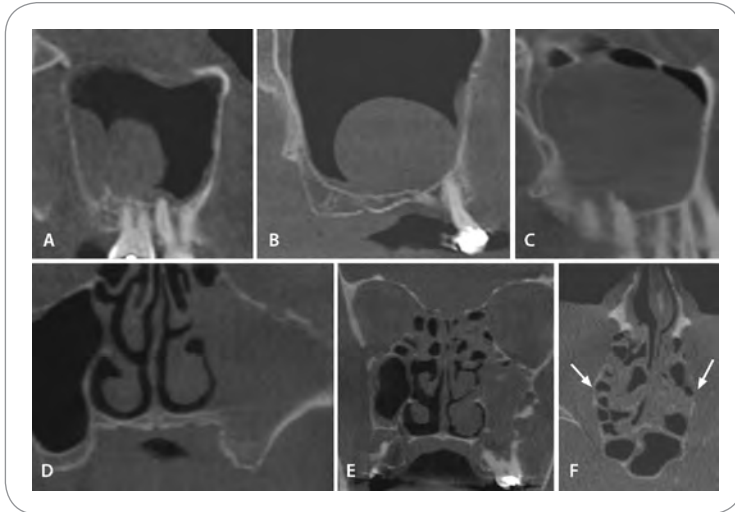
Disease of the maxillary sinuses. Data acquired using an iCAT CBCT machine. Images were reformatted in iCATVision software. (A) Sagittal view of maxillary sinus showing antral polyps. (B) Sagittal view of maxillary sinus showing retention phenomenon. (C) Sagittal view of maxillary sinus showing mucocoele. (D) Coronal view of maxillary sinus showing non-Hodgkin's lymphoma. Panels E and F are from the same patient. (E) Coronal view of the maxillary sinuses showing sinonasal polyposis. Note prominent destruction of the lateral wall of the left maxillary sinus. (F) Axial view through ethmoid air cells. Note lateral expansion (arrows) of the ethmoid walls and intact septa of the air cells.
